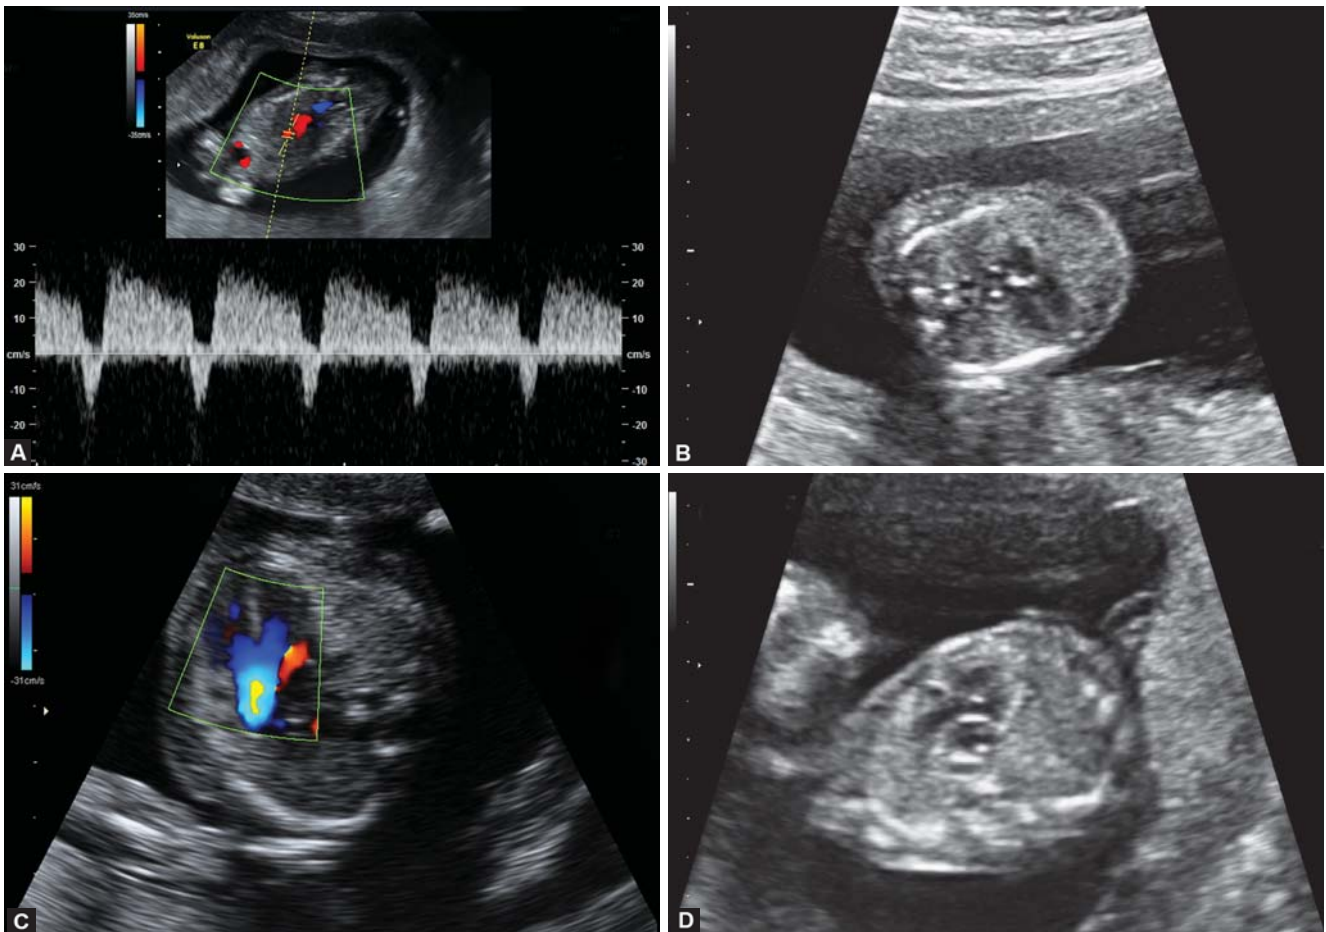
to D: Myocardial fibroelastosis and stenotic atresia at 12 weeks' gestation. *Note:* The mitral regurgitation and the fibroelastosis (A) and the reverse flow in pulmonary veins (B), myocardial fibroelastosis in 2D (C) and color Doppler (D)
